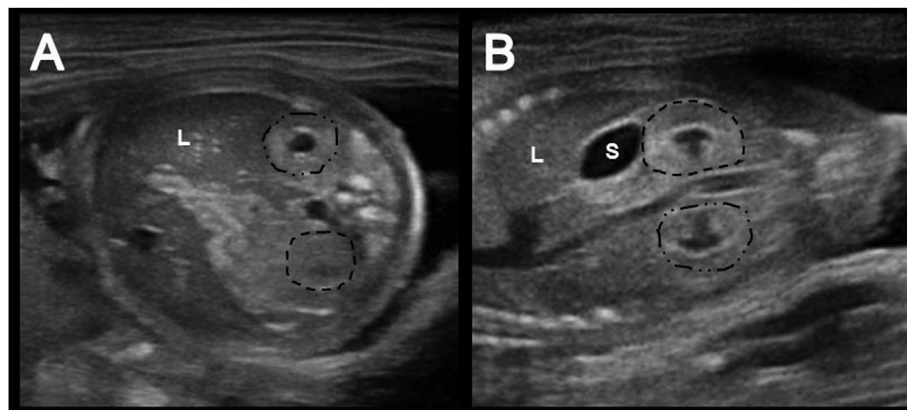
Ultrasonographic imaging of canine fetus demonstrating: (A) Fetal abdomen in transverse plane with right kidney (dots and dashes) adjacent to the liver (L) and left kidney (dashes) in transverse plane; (B) Fetal abdomen in the dorsal plane with right kidney (dots) and left kidney (dashes) adjacent to the stomach (S) in longitudinal plane. L, liver; S, stomach.
